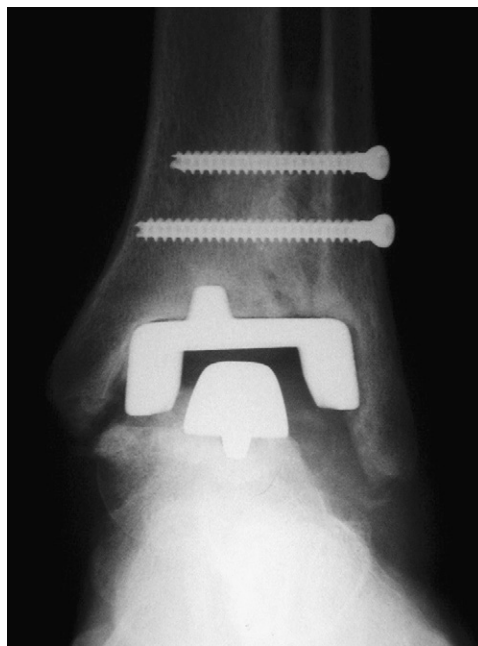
Anteroposterior radiograph of total ankle arthroplasty.
